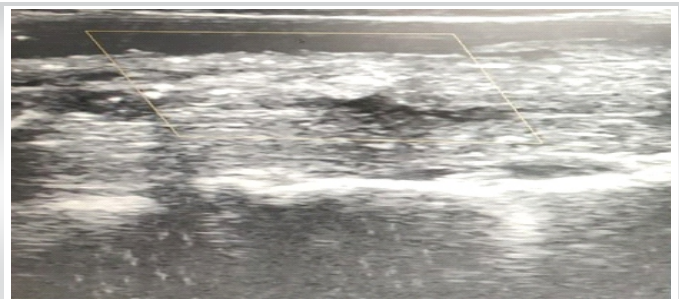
Intra op ultrasound confirming adequate ventral decompression
